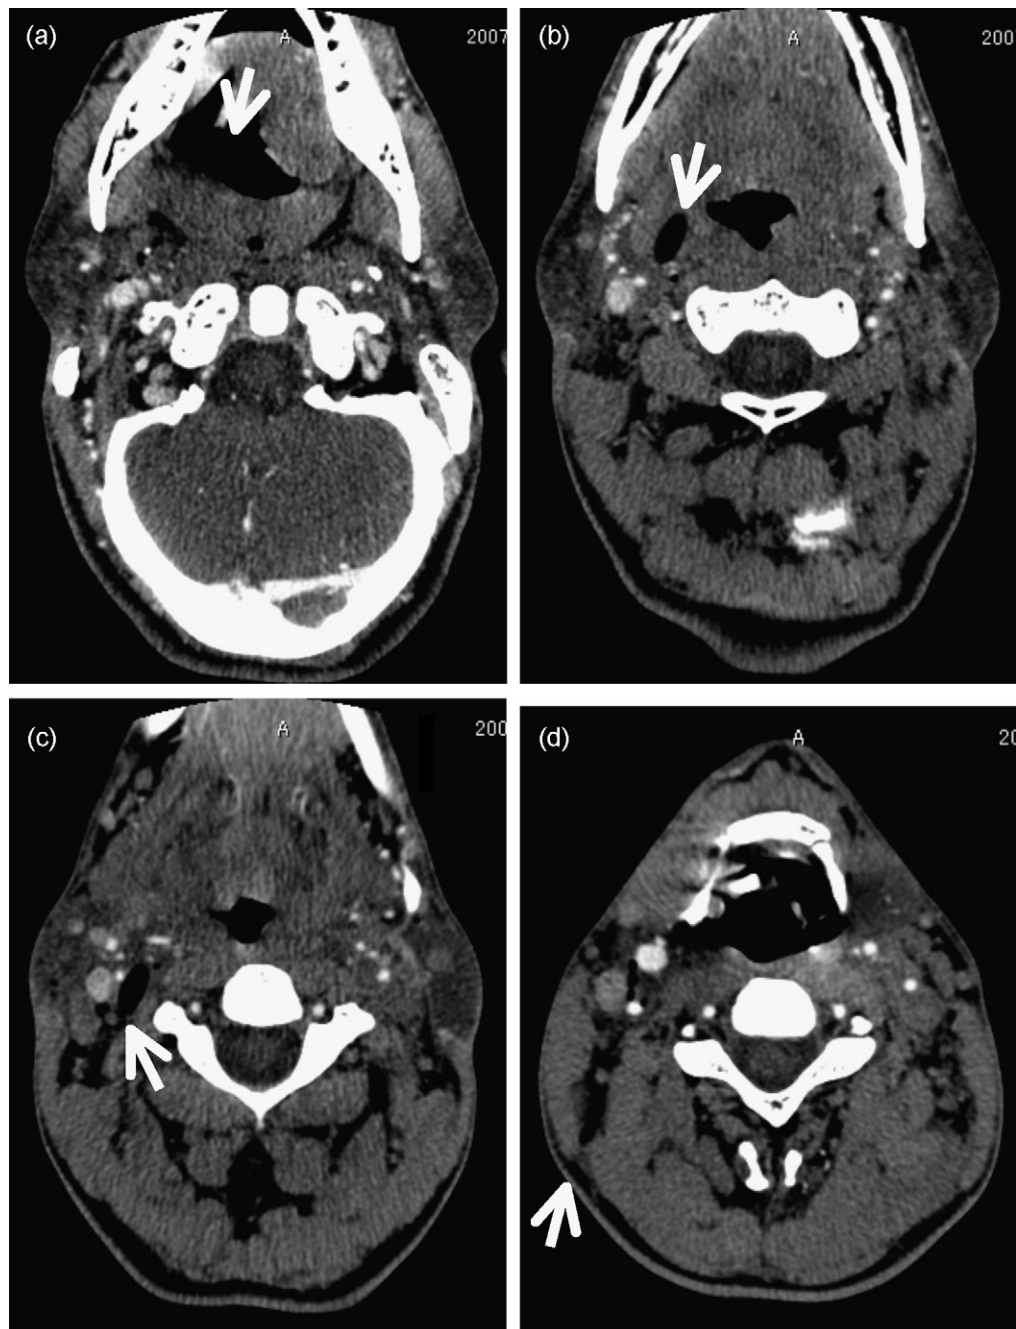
Enhanced CT on standard CT window settings. The foreign body is visualised as a non-attenuated area (arrow). It passed through the parapharyngeal space (b), traversed the deep region of the internal carotid artery (c), and reached the subcutaneous area of the posterior neck (d).
